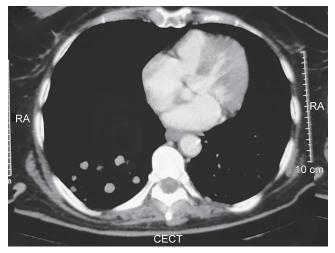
CT scan showing multiple lung metastasis
